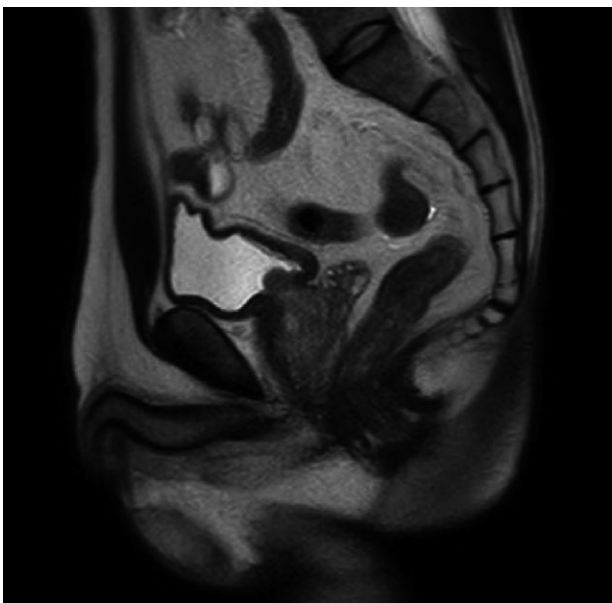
MRI finding (patient i in Fig. 1) revealed that direct apposition of the posterior bladder wall with edematous mucosa against the enlarged median lobe of the prostate protruding into the bladder.
